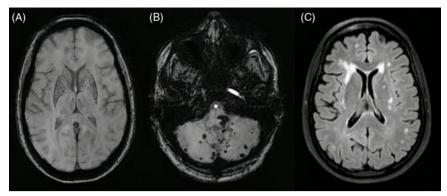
Axial SWI images (A and B) reveal predominantly cerebellar microbleeds and left pontine hemorrhage in patient 1. Axial FLAIR (C) shows confluent white matter hyperintensities.
